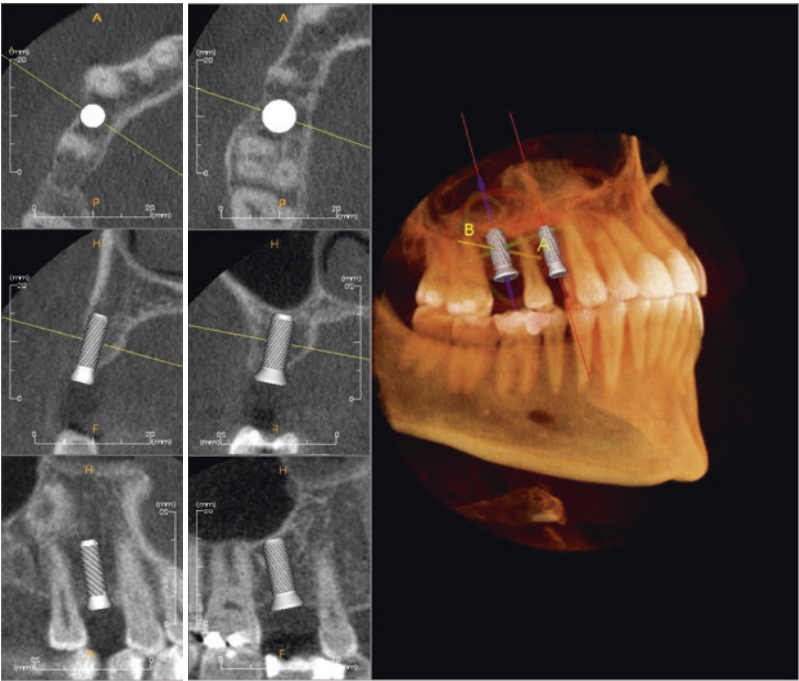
CBCT images showing an implant treatment planning program that allows virtual implant placement
